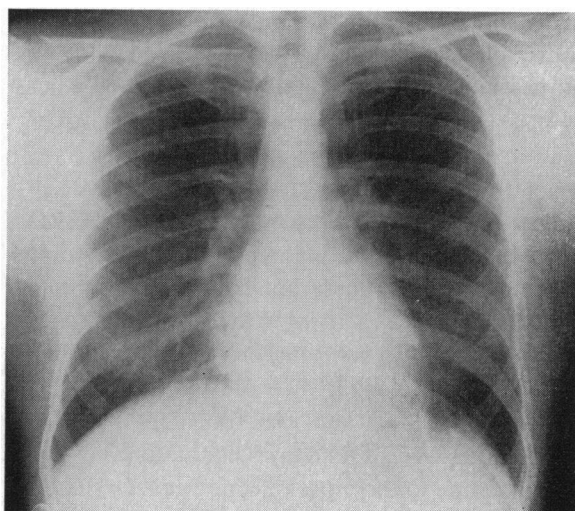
X-ray film, taken in October 1964, showing size of heart within normal limits.
